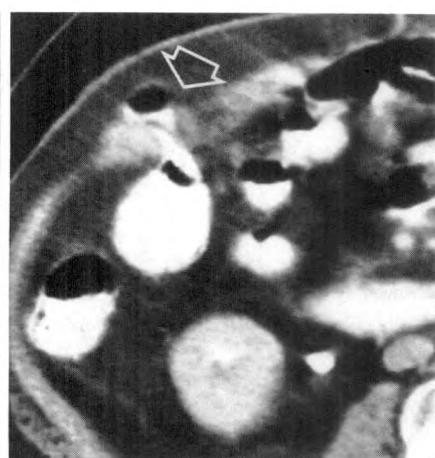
Occult incisional hernia after cholecystectomy. CT shows an intestinal loop protruding through a defect in muscular layers under right subcostal incision (arrow). Subsequent barium enema confirmed intermittent herniation of proximal transverse colon into subcutaneous fat 2 cm beneath intact skin.
